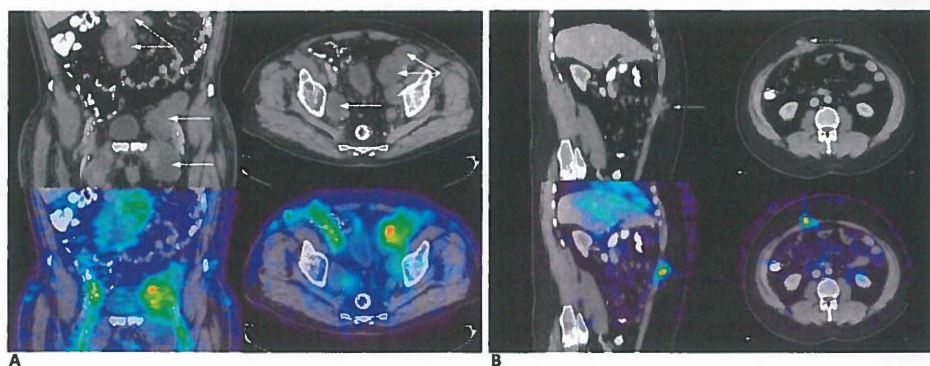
Coronal, transversal and sagittal CT images and ^{111}In -mapatumumab SPECT/CT fusion images of two melanoma patients, 3 days post-injection. (A) Tumor lesions in the upper abdomen and the left lower pelvic region show ^{111}In -mapatumumab uptake. (B) Intense ^{111}In -mapatumumab uptake in a tumor lesion in the abdominal wall. Arrows indicate tumor lesion.
